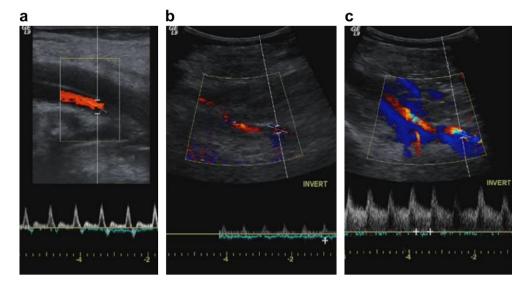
Doppler findings with FPS a) Popliteal artery longitudinal duplex scan in neutral position. b) Same popliteal longitudinal scan with plantar flexion. c) Reactive hyperaemic response following resumption of normal position.
